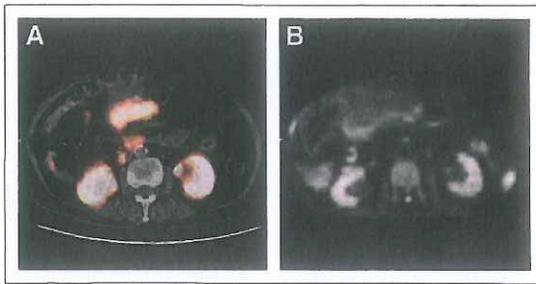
A 77-y-old woman with NET of unknown origin. ^{68}Ga -DOTATATE PET/CT (A) showed multiple liver metastases and mesenteric nodule, whereas WB DWI (B) did not identify mesenteric nodule.
